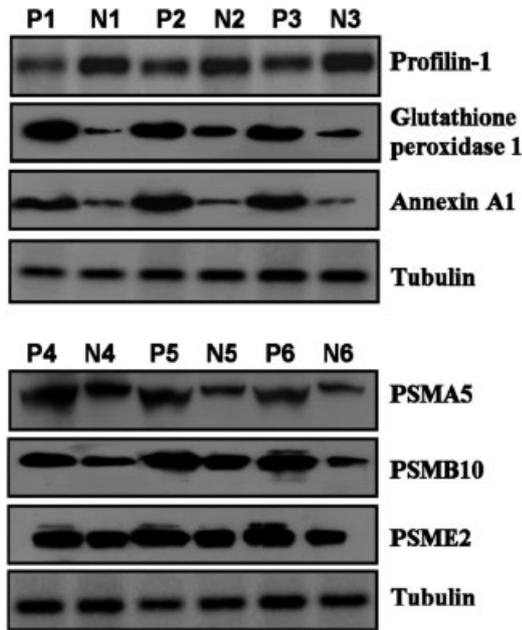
Western blot images for six proteins and internal control protein tubulin. Western blotting shows changes in the expression levels of profilin-1, glutathione peroxidase 1, annexin A1, PSMA5, PSME2 and PSMB10 in MM (P) and NPC (N).
